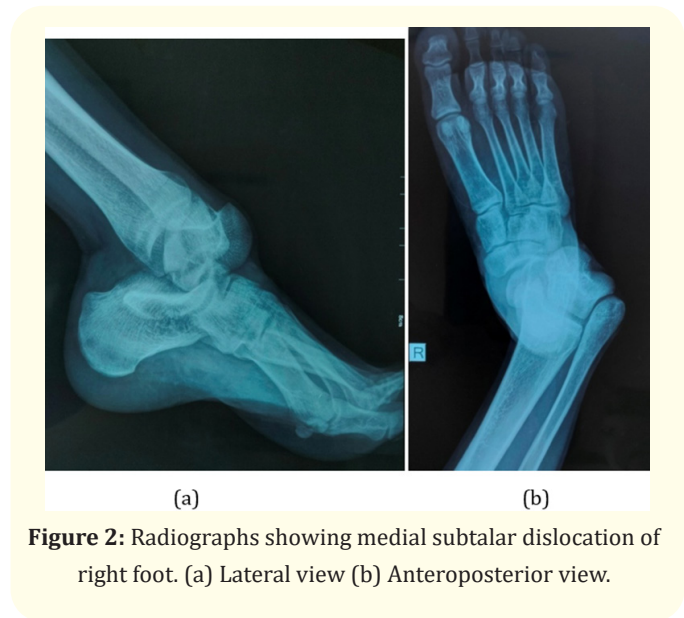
Radiographs showing medial subtalar dislocation of right foot. (a) Lateral view (b) Anteroposterior view.
